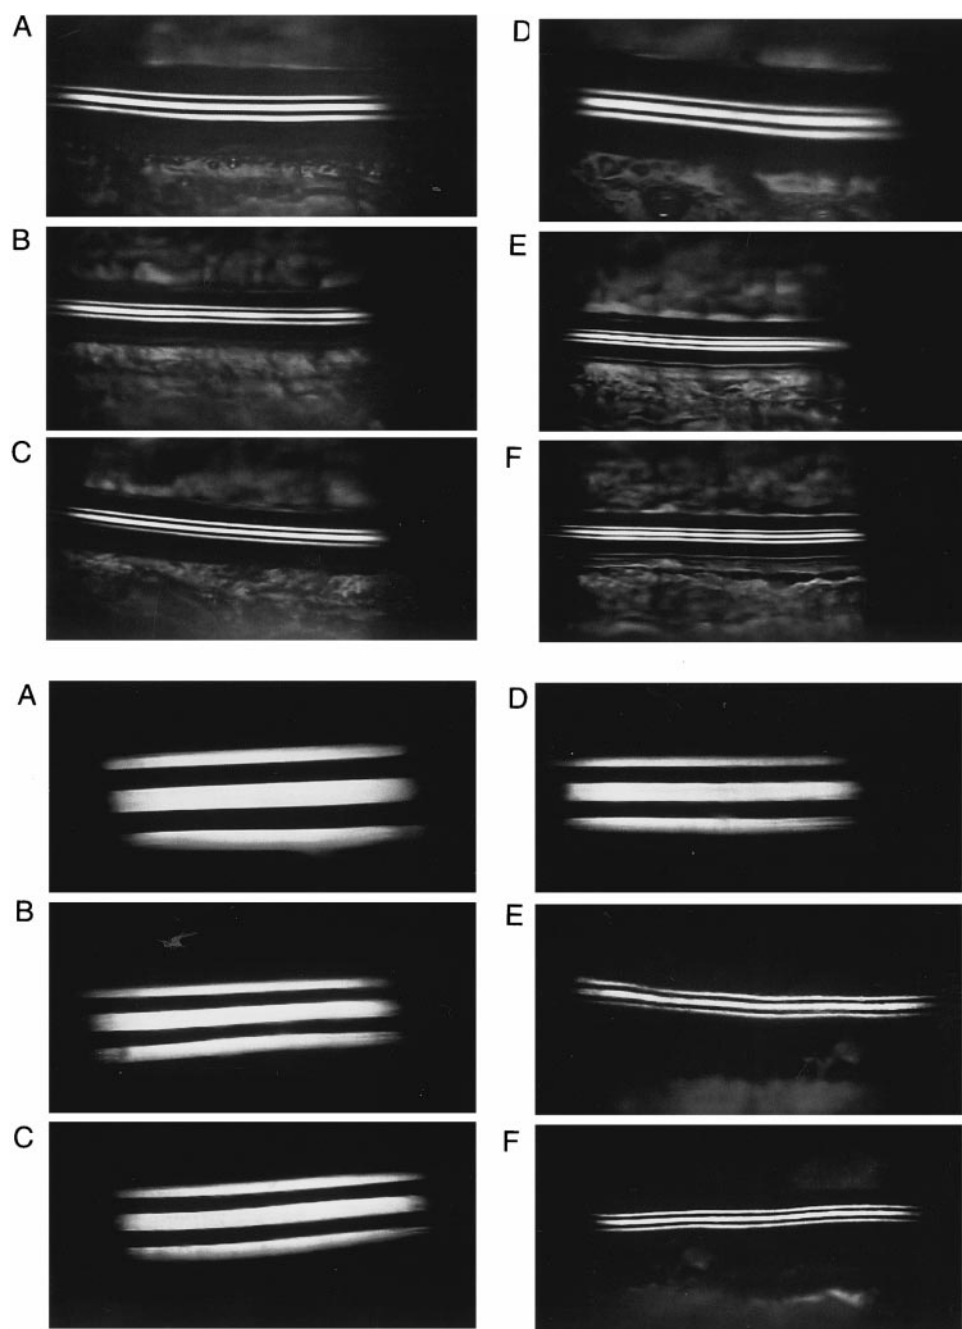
Change in meniscus images observed by meniscometry system. *Left:* CT-T (A) before test, (C) during test at 30 seconds, and (E) during test at 60 seconds. *Right:* S-T (B) before test, (D) during test at 30 seconds, and (F) during test at 60 seconds in normal (*top*, A through F) and dry eye (*bottom*: A through F).
